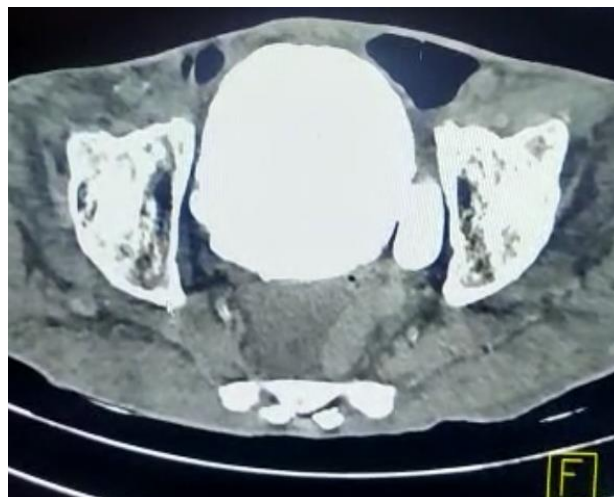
CT Cystogram image defining the vesical diverticulum.
